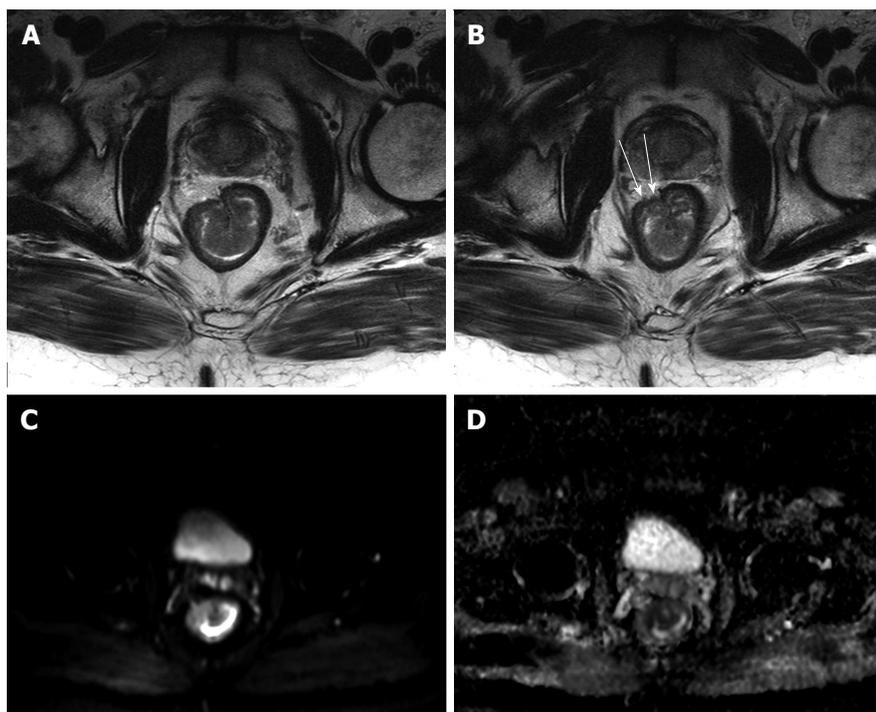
Stage T3 rectal cancer. A and B: Axial high-resolution T2-weighted images as well as axial (C) diffusion-weighted imaging ($b = 650 \text{ s/mm}^2$) and (D) ADC map images. There is a large polypoidal mass lesion arising from the right anterolateral lower rectal wall (A and B) with two foci of tumoral extension beyond the low-signal serosal layer (arrows, B) that show diffusion restriction (C and D) in keeping with stage T3 rectal tumor. ADC: Analog-digital conversion.
